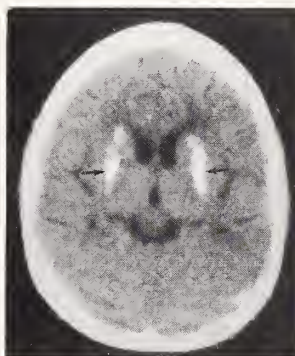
Bilateral calcification of the basal ganglia on CT.
